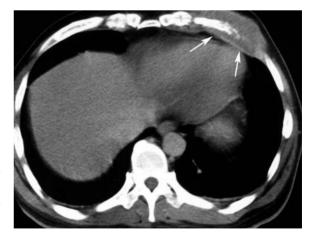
Collecting duct carcinoma in a 45-year-old man. Axial CT scan shows rib destruction with metastatic soft tissue mass (*arrows*).
